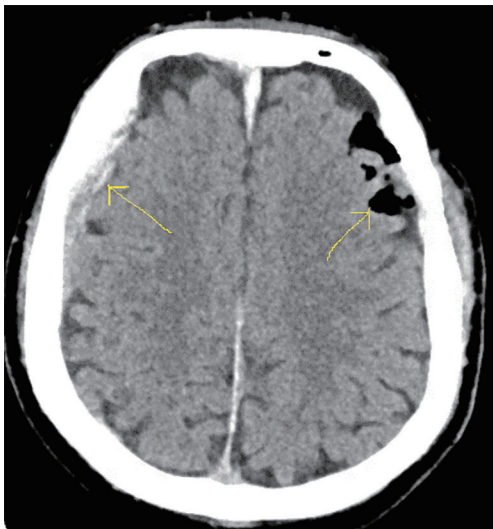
Postoperative axial brain CT scan showing acute subdural hematoma on the right side (left arrow) and pneumocephalus on the left side (right arrow).
